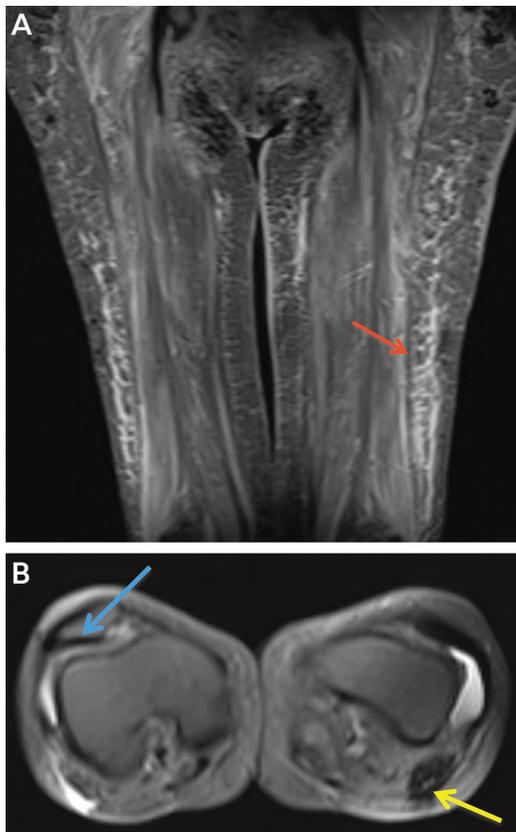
Thigh muscle MRI of a patient with severe dermatomyositis. *A*, Hyperintensity is seen throughout the subcutaneous tissue (red arrow; coronal section, short tau inversion recovery sequences). *B*, Axial image of the thigh shows marked muscle atrophy (blue arrow) indicating severe disease and subcutaneous calcifications in the posterior thigh (hypointensity, yellow arrow).
